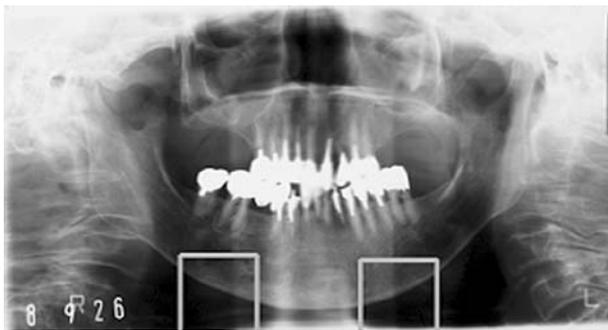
Two boxes correspond to the area below the mental foramen on the left and the right sides of the mandible on digitized dental panoramic radiographs
